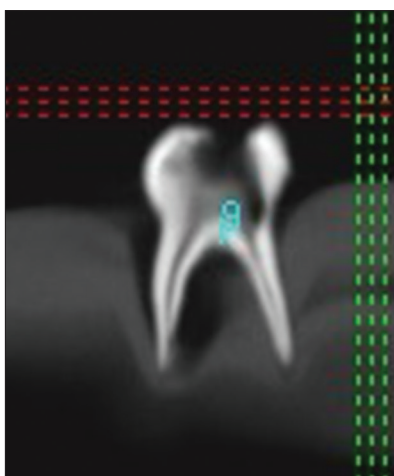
Cone beam computed tomography showing lower E sample's measurement between the floor of the pulp chamber to furcation
